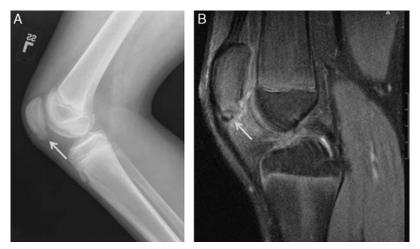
An ossicle (arrow) at the inferior pole noted on both the plain radiograph (A) and MRI (B) with increased signal around the ossicle noted on MRI. (Courtesy of Paul Saluan, MD, Cleveland Clinic Foundation). MRI indicates magentic resonance imaging.
